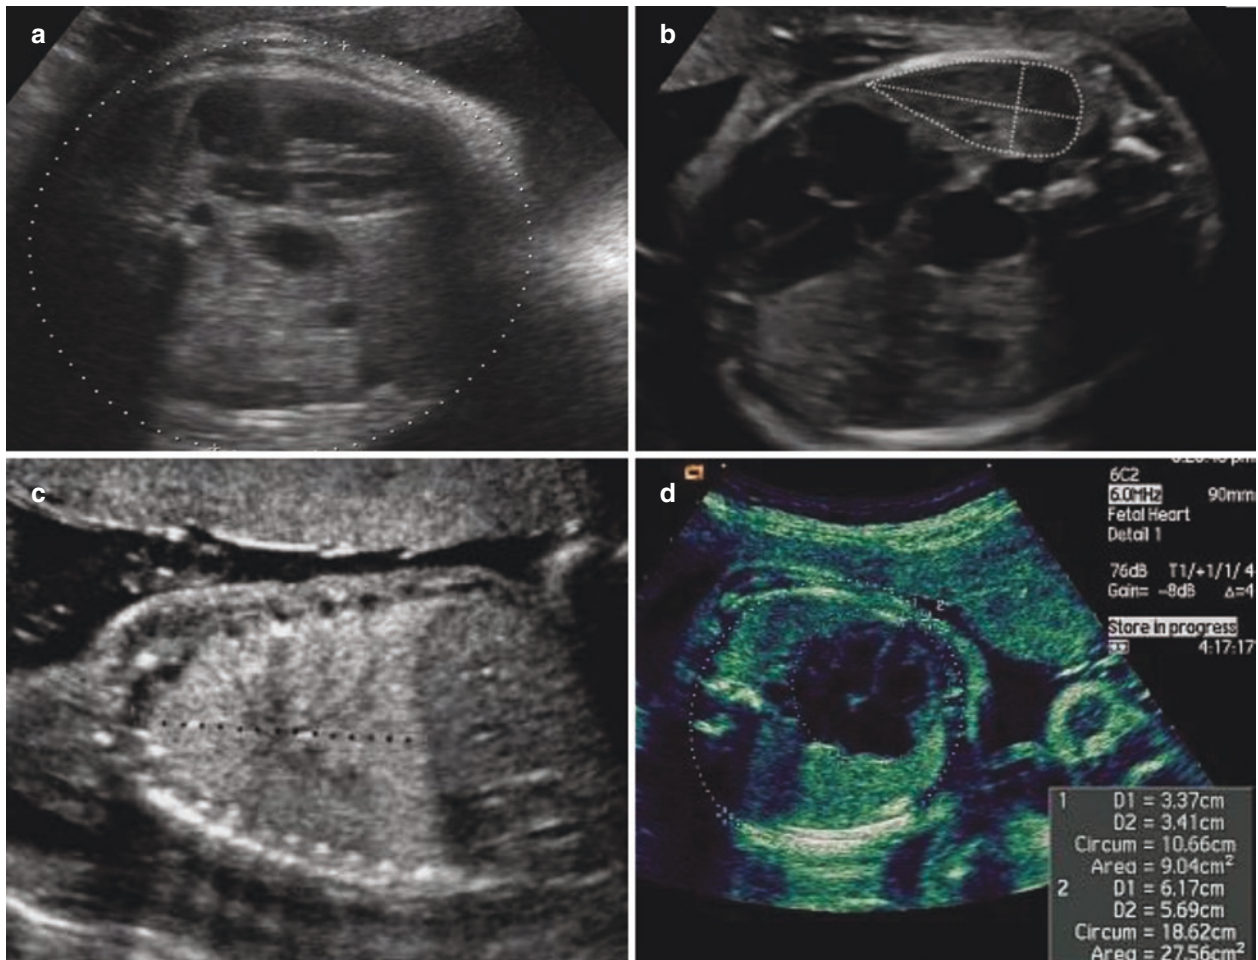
Common 2-D ultrasonic parameters of pulmonary dysplasia. (a). Chest circumference. (b). Pulmonary area. (c). Pulmonary length. (d). Cardiothoracic ratio
